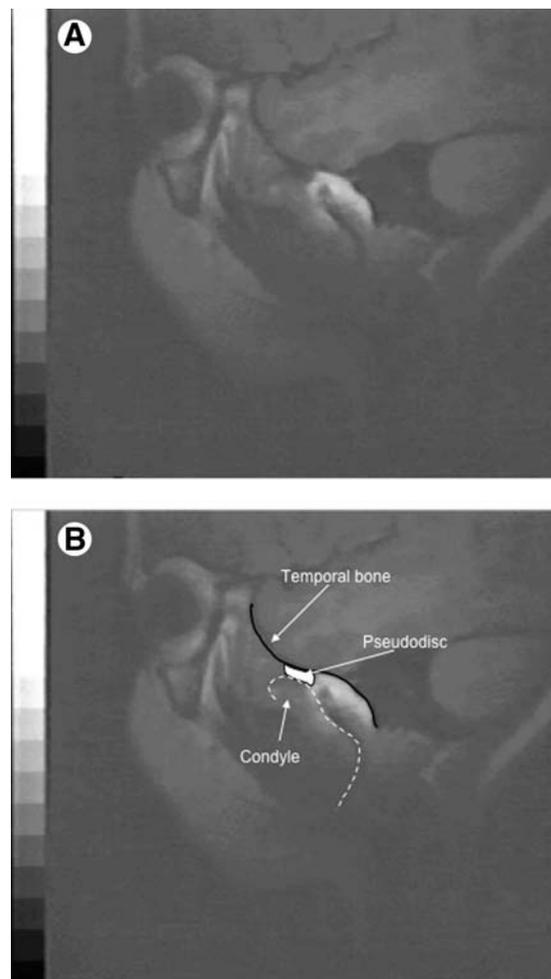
(A) The MRI of the same CFM patient seen in Figure 6 in an open position shows atypical displacement of the condyle. The relationship between the condyle, temporal bone and disk is abnormal. The pterygoid muscles are poorly defined. (B) Outline and labels for A.
